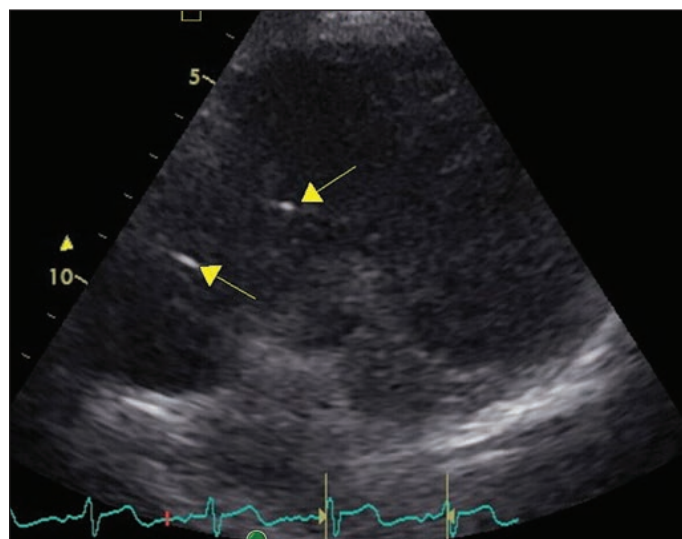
Transthoracic echocardiography guided shunt-o-gram.
